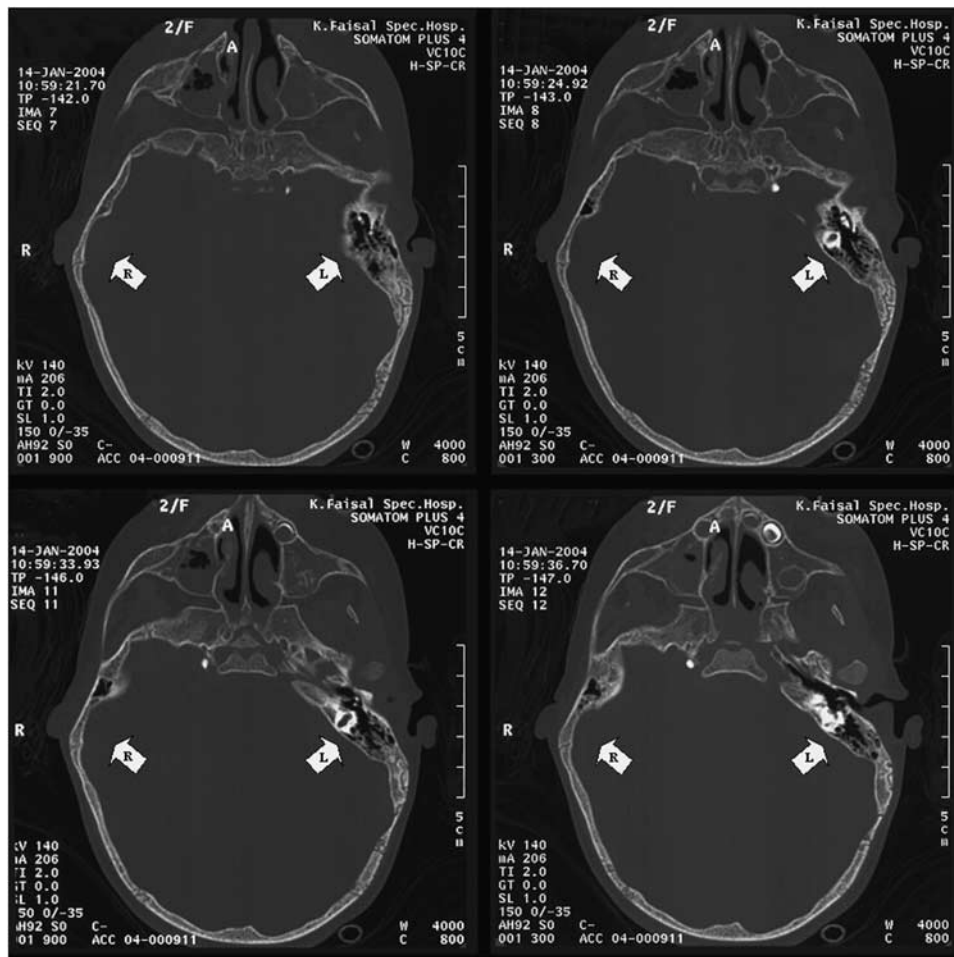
CT scans of the temporal bones. All four panels are showing asymmetric tympanic cavities. On the right side vestibular or cochlear system was not visualized; however, a cystic vestibulum was recognized on the left side.
